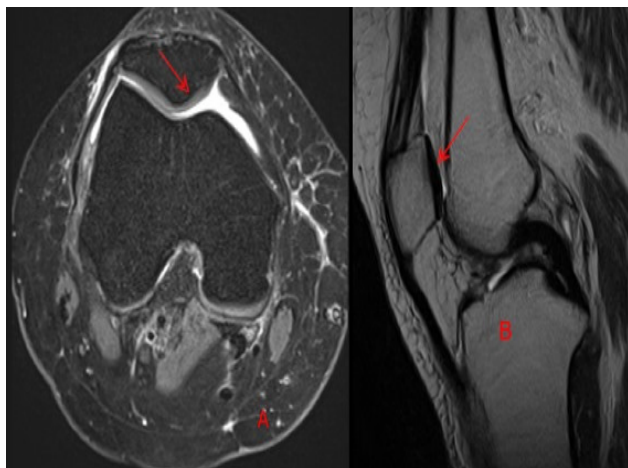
MRI before PRP injection, (A) Axial T2WI revealed denuded articular cartilage and (B) sagittal STIR images revealed: denuded articular cartilage with subchondral bone edema.
